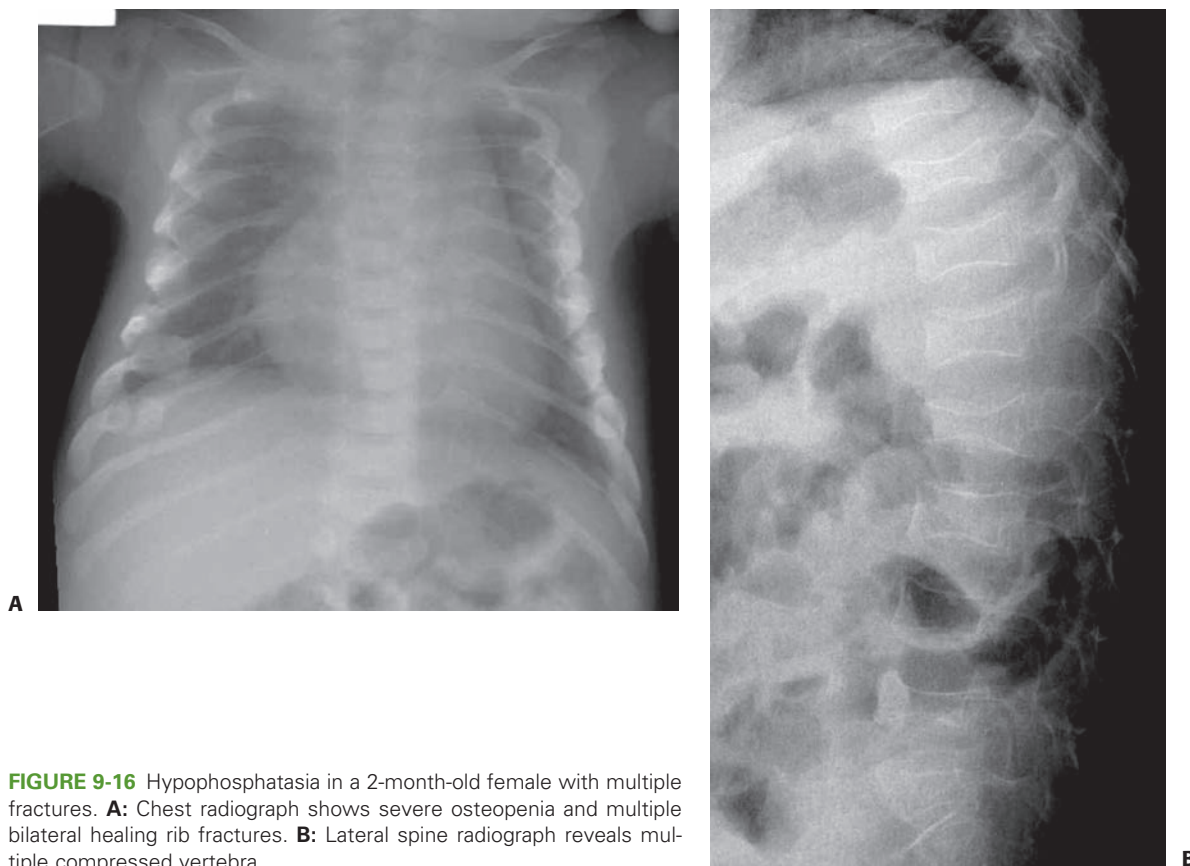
Hypophosphatasia in a 2-month-old female with multiple fractures. A: Chest radiograph shows severe osteopenia and multiple bilateral healing rib fractures. B: Lateral spine radiograph reveals multiple compressed vertebra.
